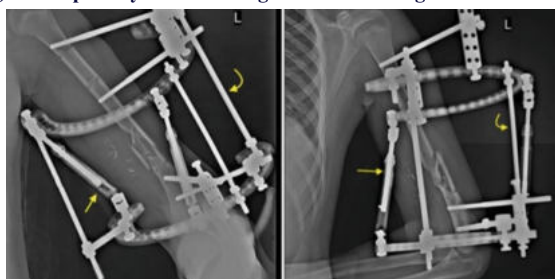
Post Op X-ray of External Fixator application for a comminuted humeral diaphyseal fracture.
